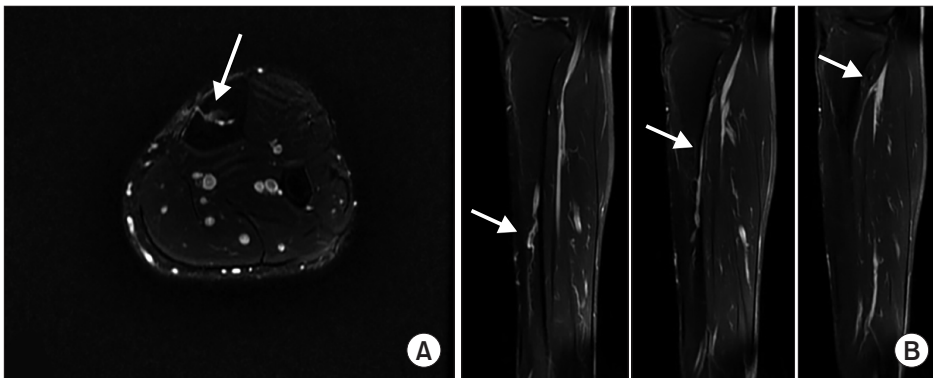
Magnetic resonance imaging findings. (A) On an axial view, the intraosseous vascular structure was found to be communicating with the superficial vein (arrow). (B) On a sagittal view, the intraosseous vessel was shown to originate from the popliteal vein (arrows).
